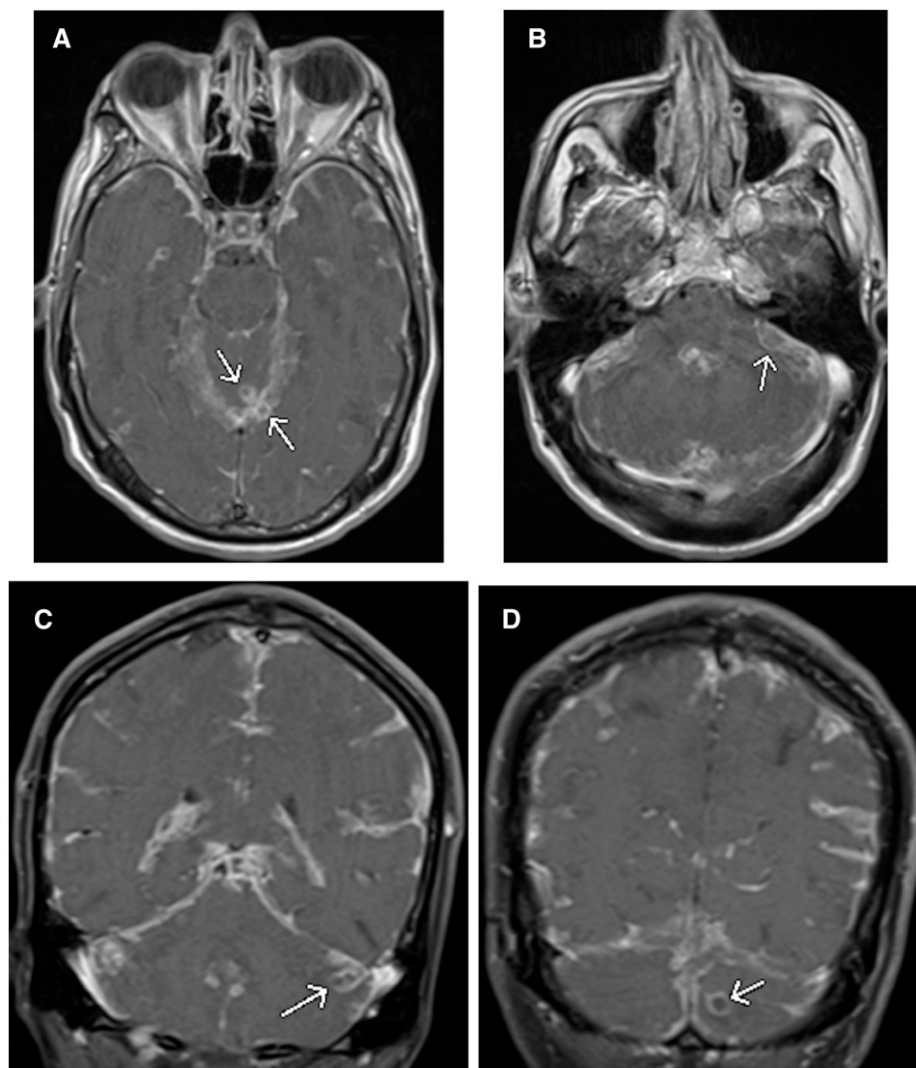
Follow-up axial (A and B) and coronal (C and D) contrast-enhanced T1-weighted MRI images show worsened leptomeningeal enhancement and new ring-enhancing parenchymal abscesses abutting the tentorium and within the left cerebellar hemisphere (arrows).
